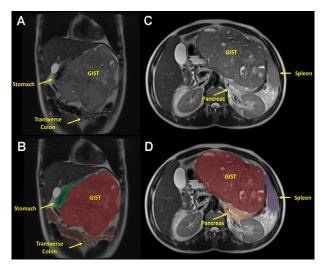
Giant exophytic gastric GIST. A) Preoperative MRI shows a large gastric GIST displacing the transverse colon. B) As in A with highlighted anatomical structures. C) Preoperative MRI shows a large gastric GIST displacing the distal pancreas and spleen. D) As in C with highlighted anatomical structures.
